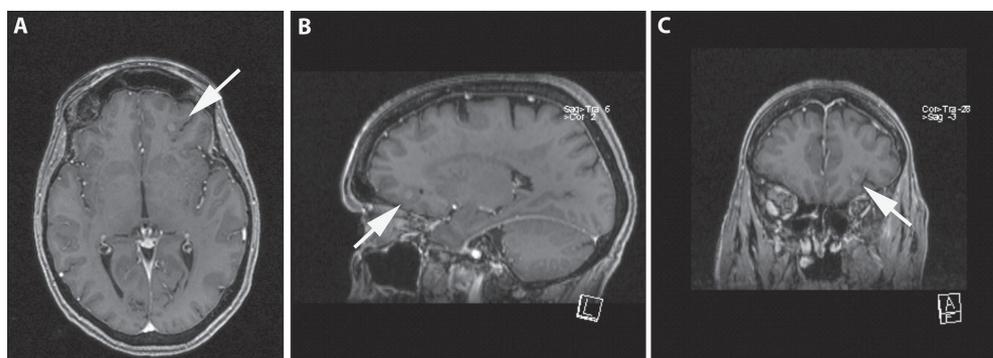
MRI showing a diffuse lesion left frontal on T1 sequences with focal contrast enhancement (A: axial, B: sagittal, C: coronal view).
